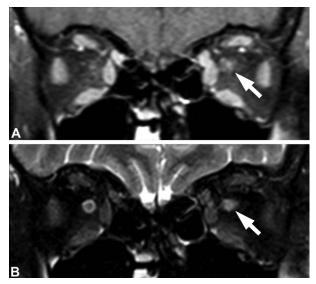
A 34-year-old man with a history of COVID-19 infection 2 months before presented with left blurry vision loss and bumping into things for 1 month. Physical examination revealed papilledema and relative afferent pupillary defect in the left eye. An orbital MRI demonstrates (A) enhancement (*arrow*) and (B) T2/STIR hyperintense signal (*arrow*) of the left retrobulbar optic nerve. STIR, short tau inversion recovery.
